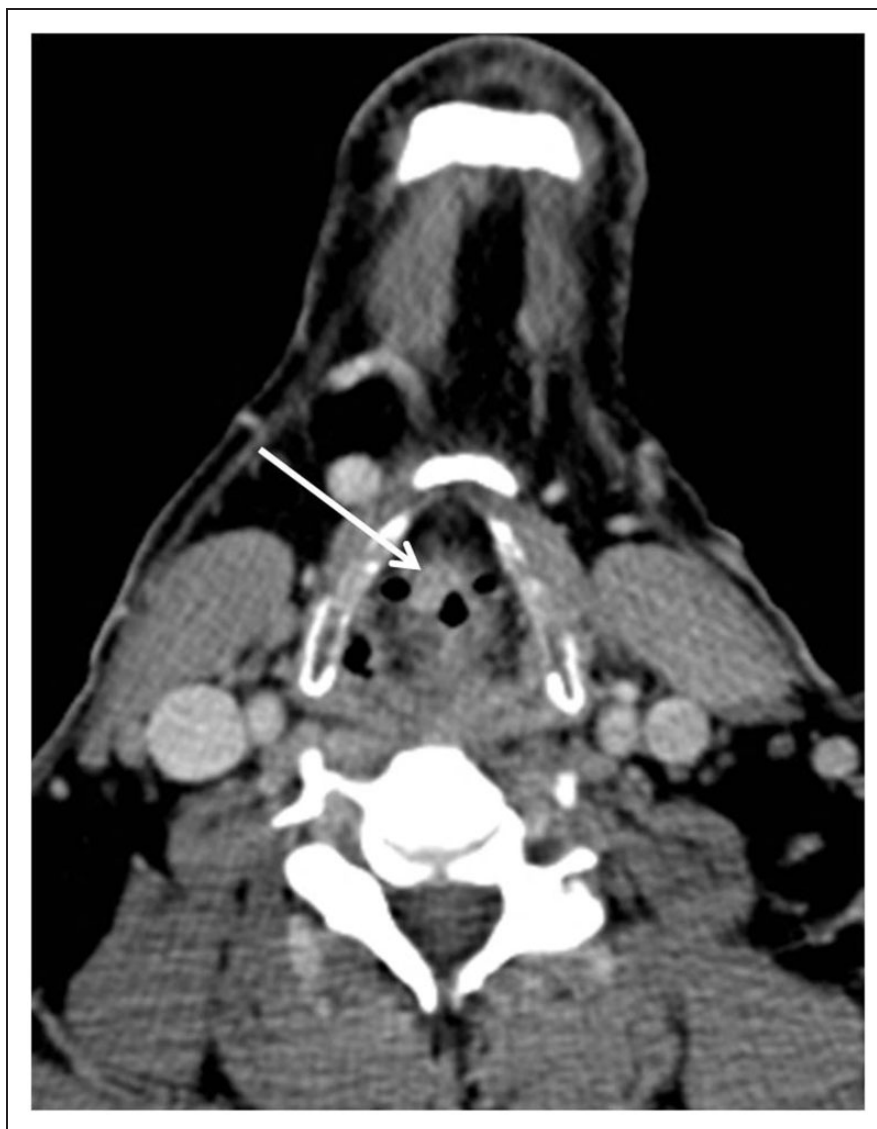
Axial contrast-enhanced computerised tomography (CT) image obtained in a 55-year-old man with supra-glottic squamous cell carcinoma (SCC) shows tumour invasion of the pre-epiglottic space (arrow).
